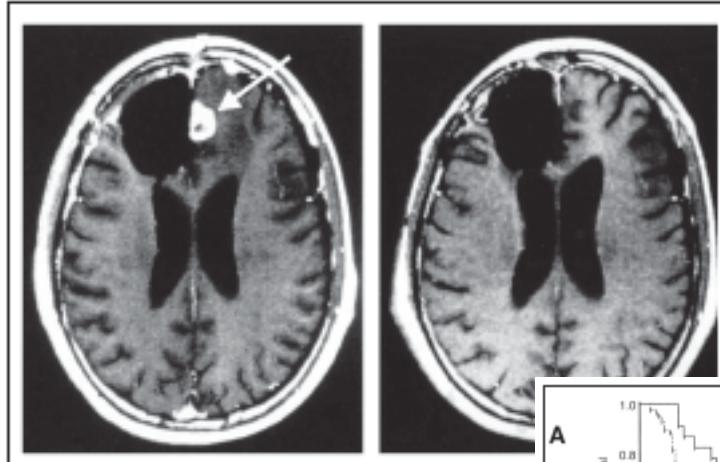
Tumor regression as evidenced by magnetic resonance imaging. Magnetic resonance imaging scans of the brain (T1 with gadolinium) of patient 4 after standard treatment (surgery and radiotherapy; left panel) and 6 months later after additional vaccination therapy (right panel). A tumor (arrow) that developed during radiotherapy completely disappeared after vaccination.
